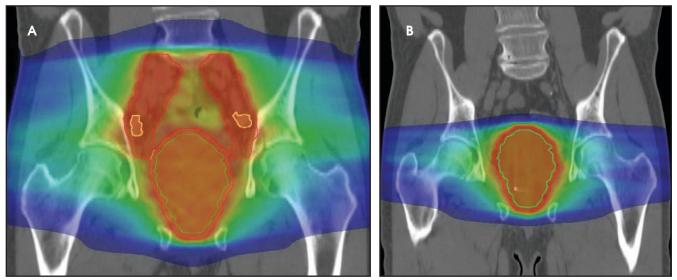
Image (A) shows the first portion of radiotherapy treatment course to 3,960 cGy in 22 fractions. Contoured structures include the prostate (green), radiographically-involved lymph nodes (yellow), and planning target volume (PTV) (red). The PTV encompasses the internal iliac nodal chains bilaterally, and a 5-mm expansion around the prostate volume. Image (B) shows the second portion of treatment course prescribed to 3,600 cGy in 20 fractions. The PTV (red) encompasses a 5-mm expansion around the prostate (green).
